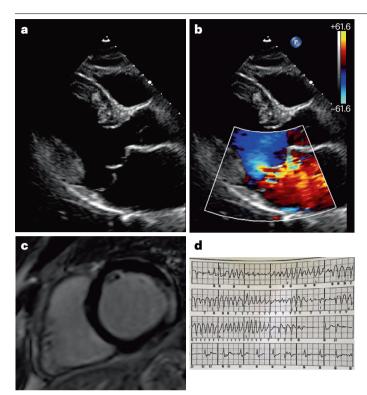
Arrhythmic mitral valve prolapse. a,b, Transthoracic echocardiographic long-axis views in end-systole of a patient with arrhythmic mitral valve prolapse show mitral valve prolapse with mitral annular disjunction and severe mitral regurgitation. c, Contrast-enhanced cardiac magnetic resonance short axis view of the same patient shows subepicardial late gadolinium enhancement, indicative of myocardial fibrosis, in the left ventricular inferolateral basal wall. d, 24-h Holter monitoring showing non-sustained ventricular tachycardia.
